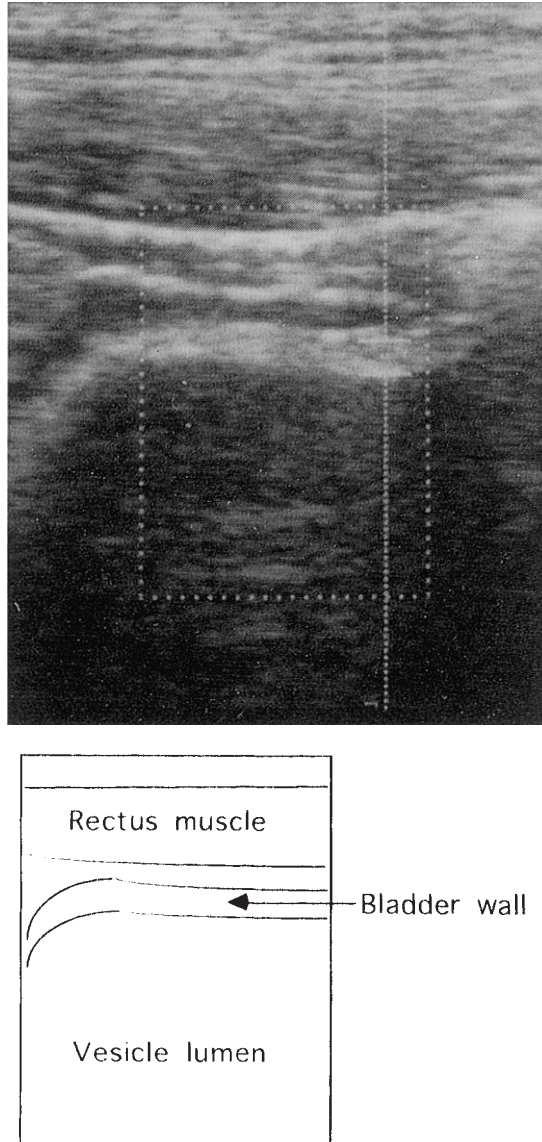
Transabdominal sonogram of anterior bladder wall of 33-year-old patient with male infertility (control group). No blood flow was detected.
